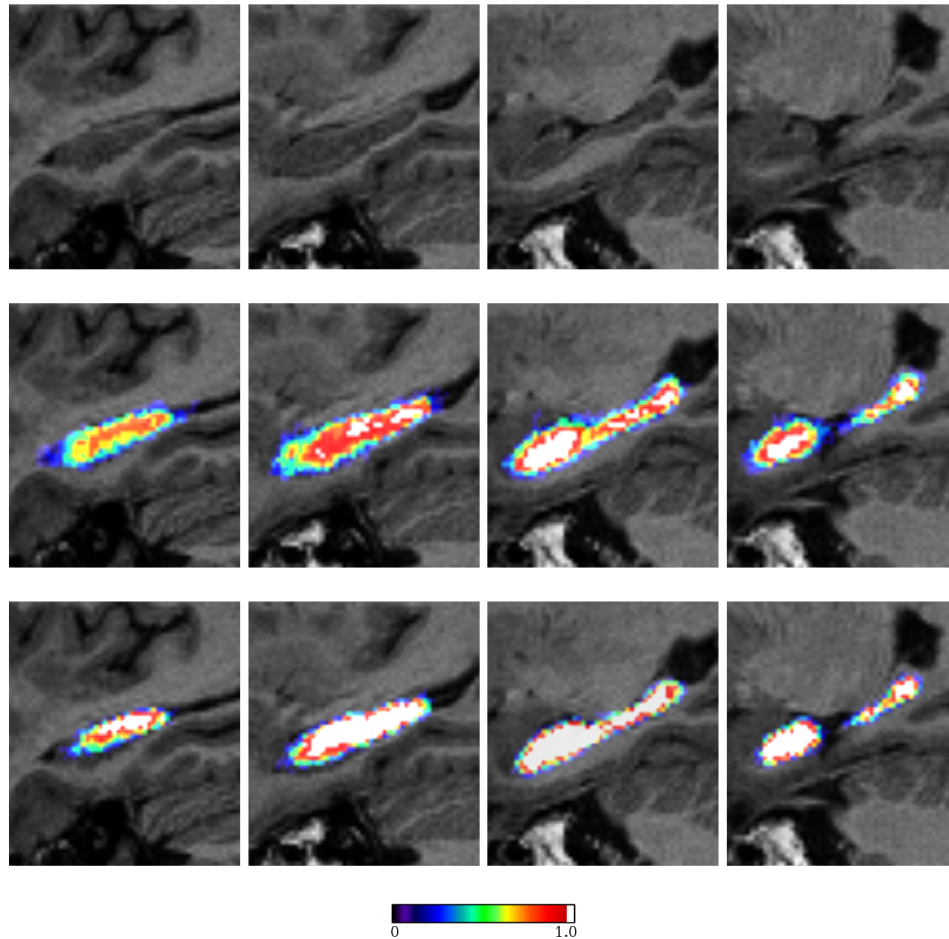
Probability images of hippocampus of the same NC subject, with the white colour indicating unanimous agreement. Top: T1-weighted MR images of hippocampus; middle: the probability images fusing 9 propagated atlases from IBSR, selected according to image similarity; bottom: the probability images fusing 9 atlases propagated from population specific atlases, selected according to image similarity.
